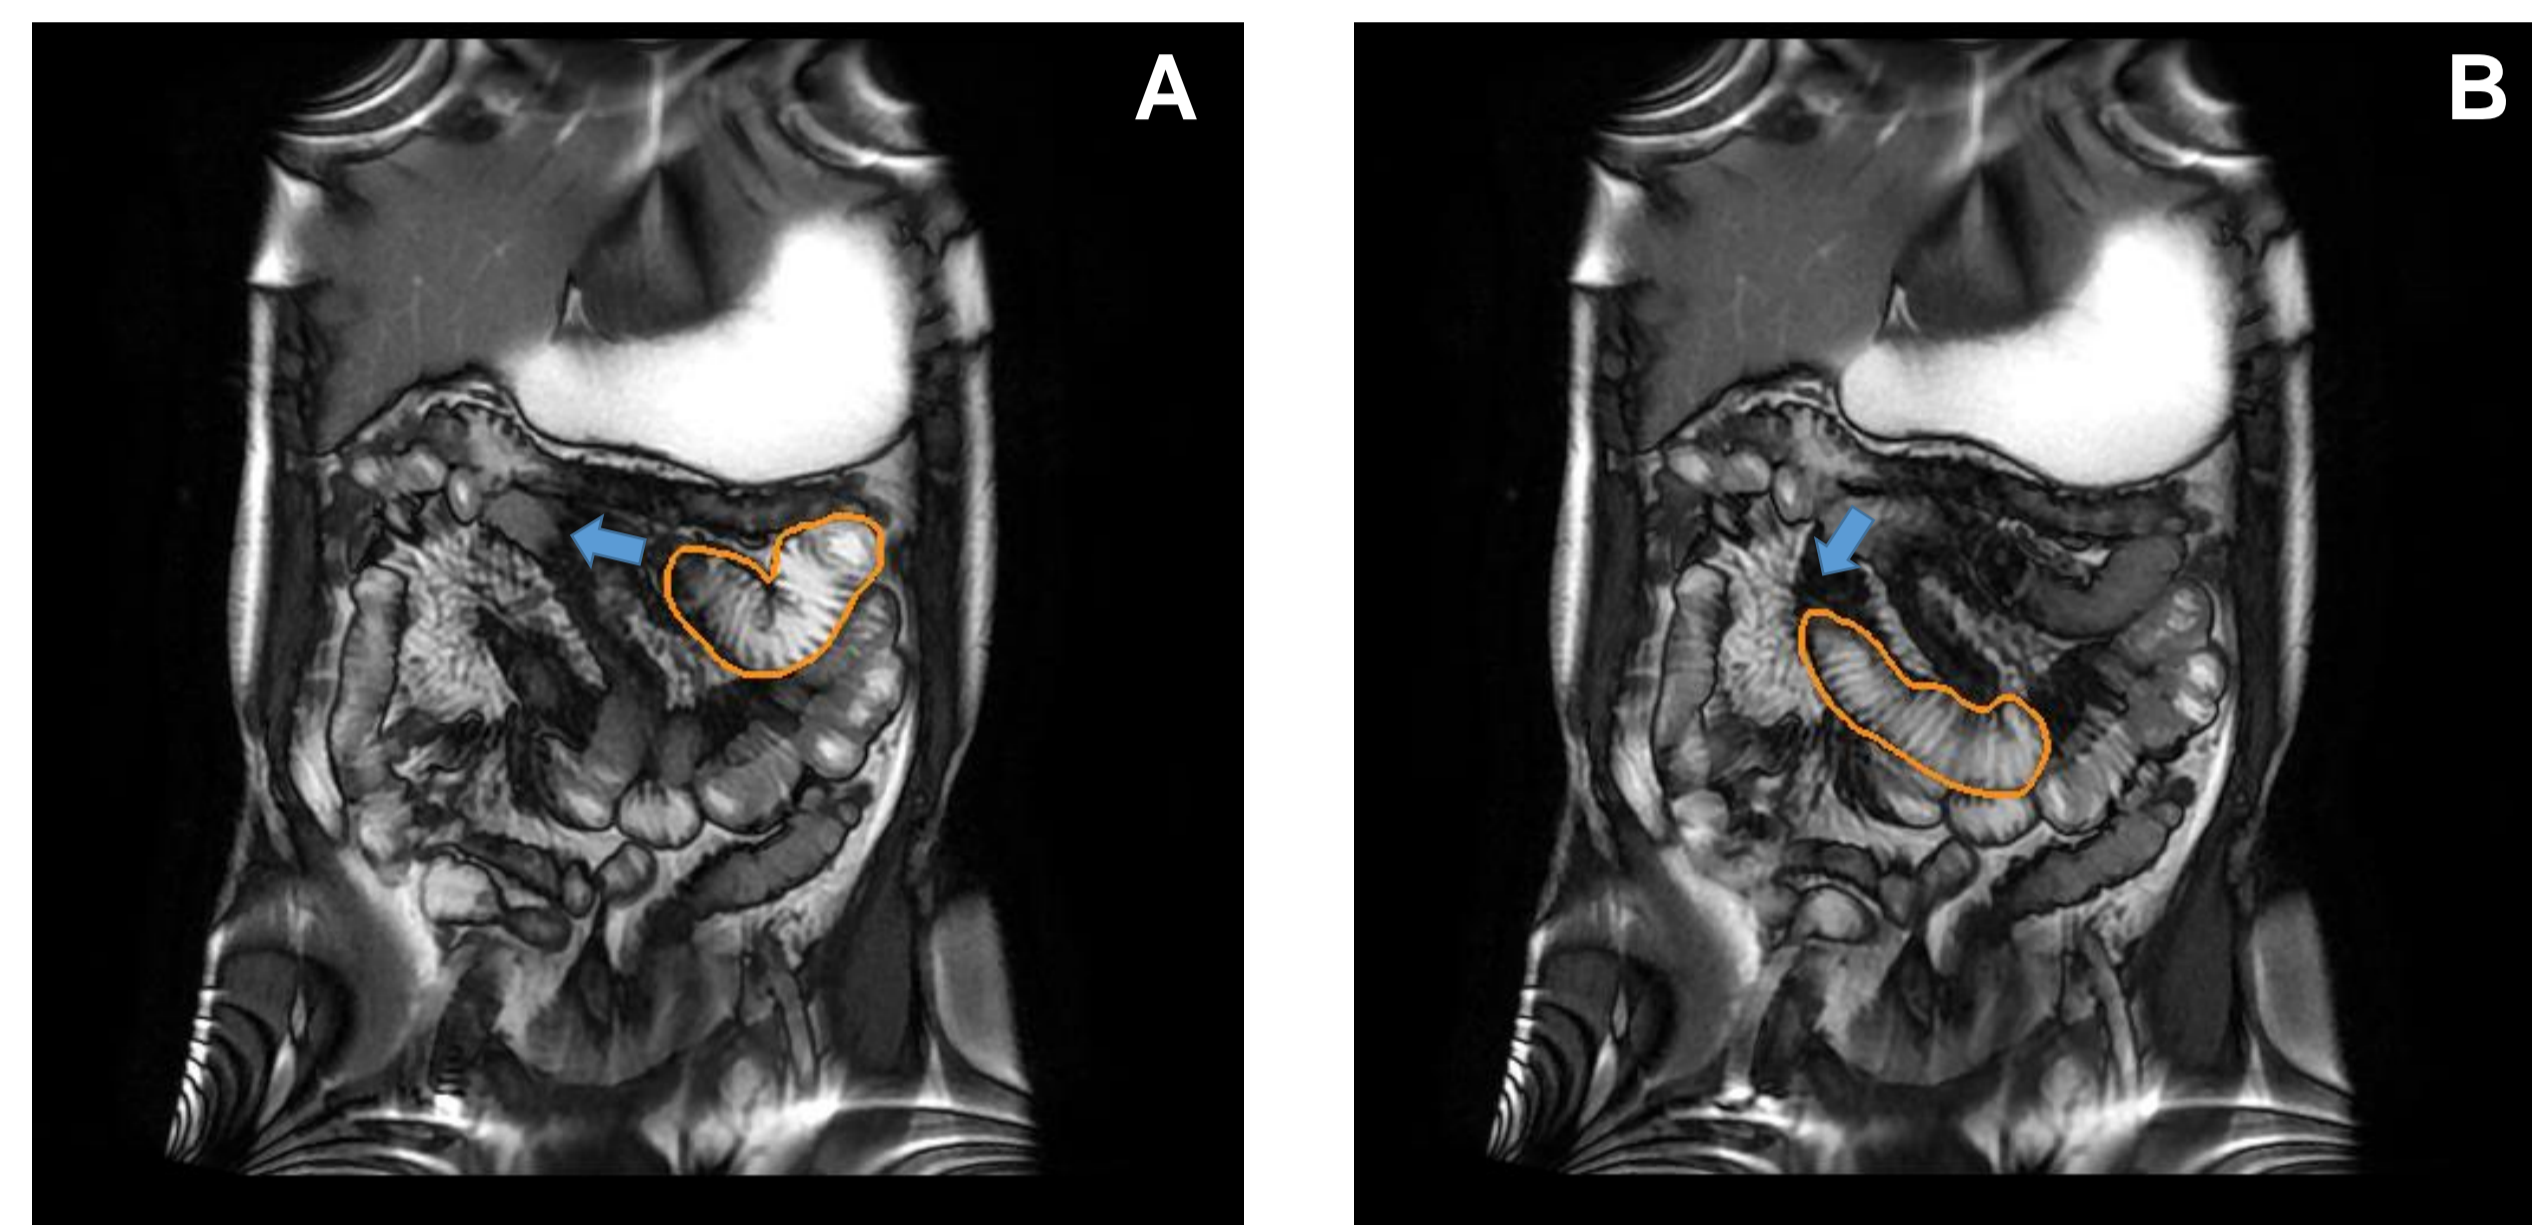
Abdominal MR images after ingestion of 1500 mL water. White areas show high water concentration. The orange areas show the progression of water. Image (A) is scanned 7.2 seconds before image (B).
